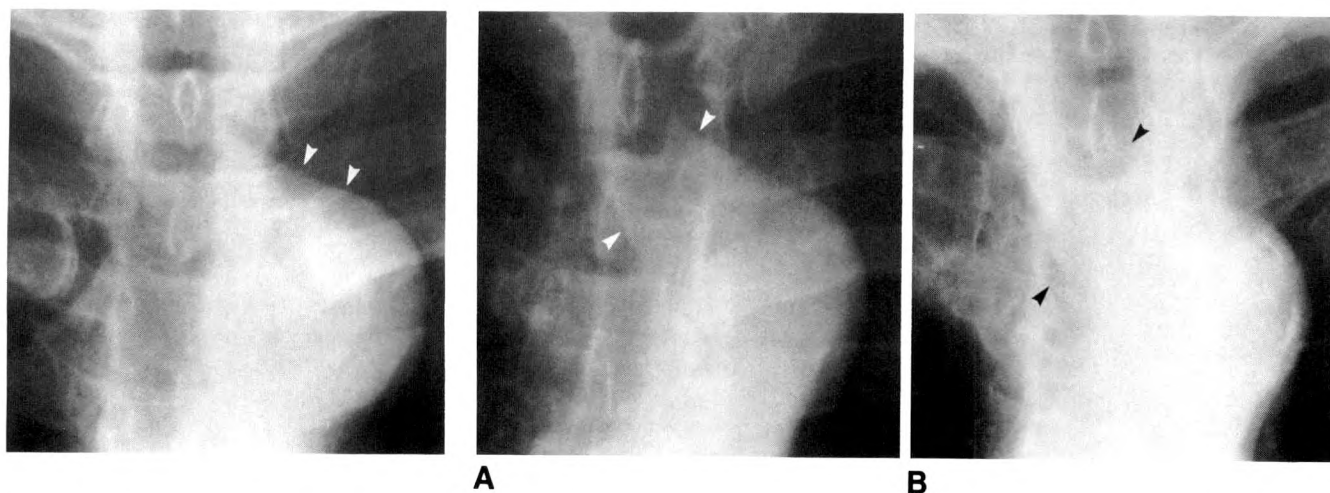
Oblique edge. Posteroanterior radiograph shows oblique edge of aberrant right subclavian artery (arrowheads) extending to right from aortic knob.
